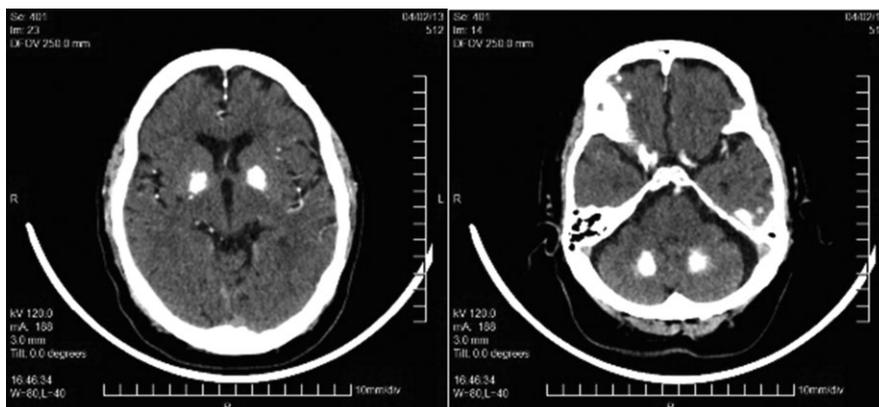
Computed tomography scan of the brain, transversal vision showing the calcifications in the basal ganglia and in the cerebellar dentate nuclei.
